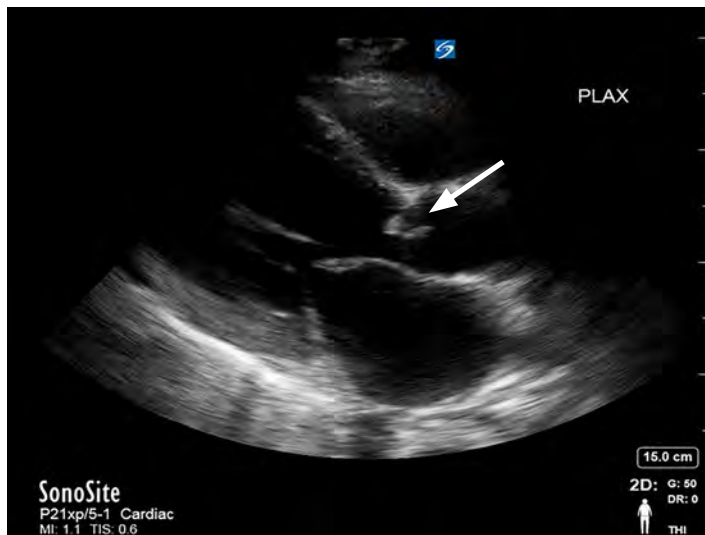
Aortic vegetation: Parasternal long-axis view showing a mobile oscillating mass on the aortic valve (arrow).
